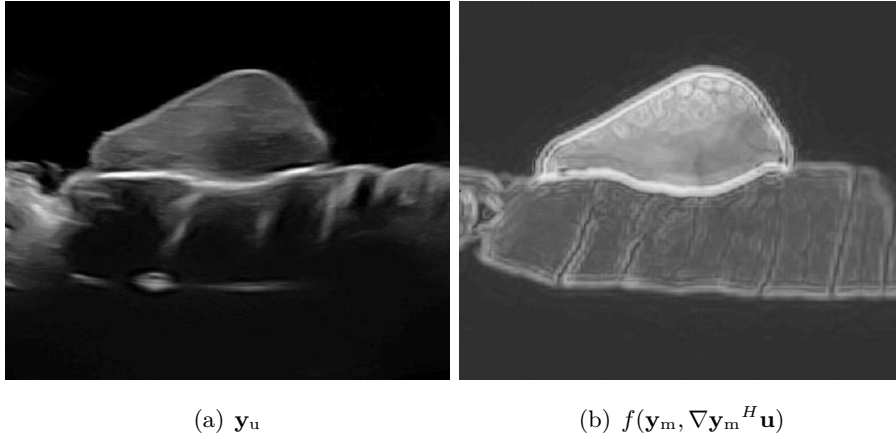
(a) US image, (b) MR image obtained after applying the estimated polynomial function, representing the same imaged medium. The original MR image is shown in Fig. 4.5(b)
